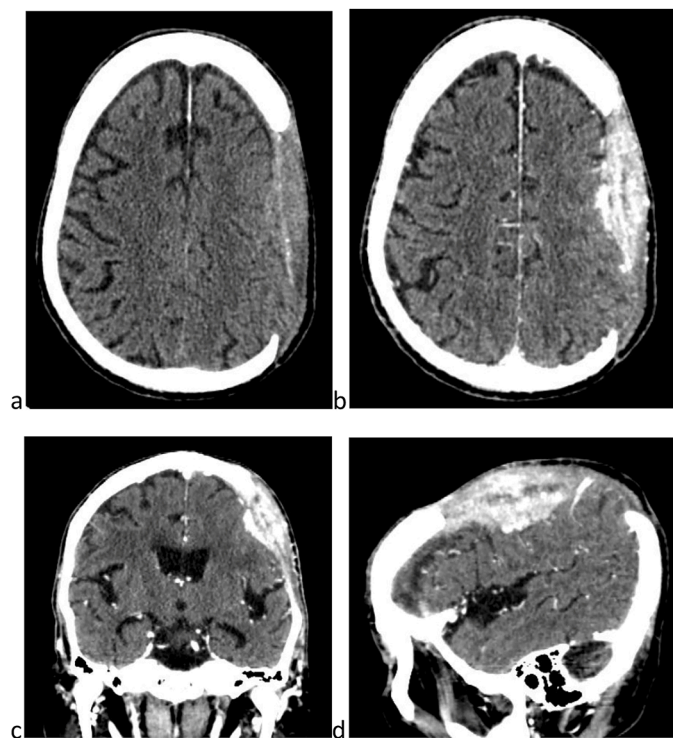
a. CT scan showing an extraaxial swelling in the craniectomy site with compression of brain. b. Enhancement of tumor with contrast, suggestive of metastasis. c. Coronal view of the contrast enhancing growth. d. Sagittal view of the tumor.
